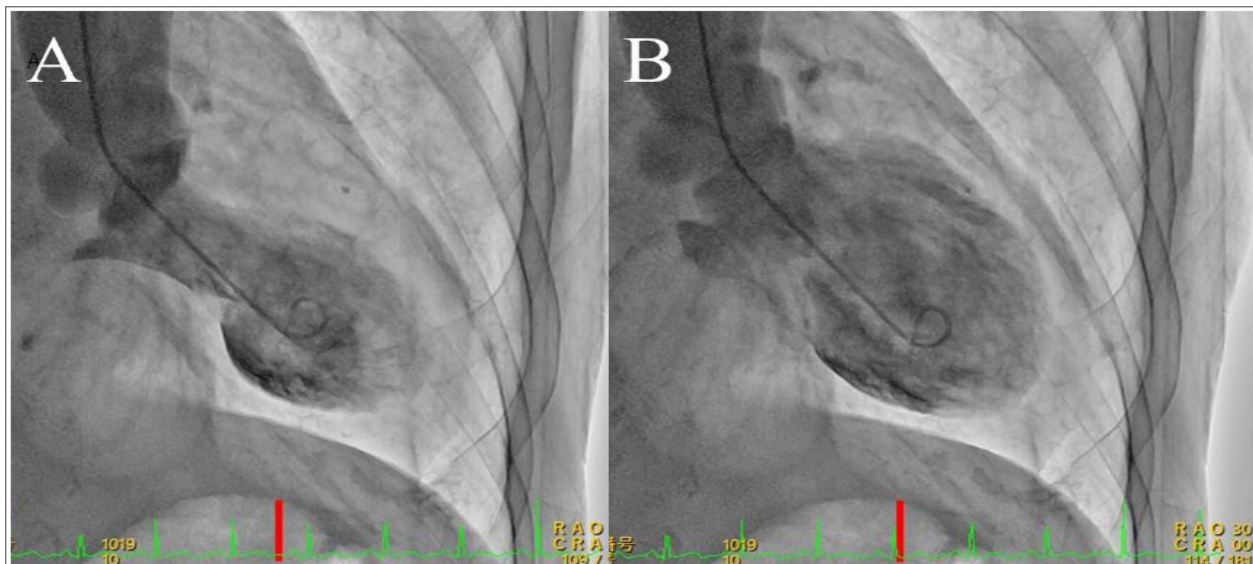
Cardiographic findings regarding left ventricular wall motion. The morphology of the left ventricle was assessed under radiographic guidance using an iodine-based contrast agent. (A) It shows the morphology of the left ventricle during systolic phase. (B) It shows the morphology of the left ventricle during diastolic phase.
